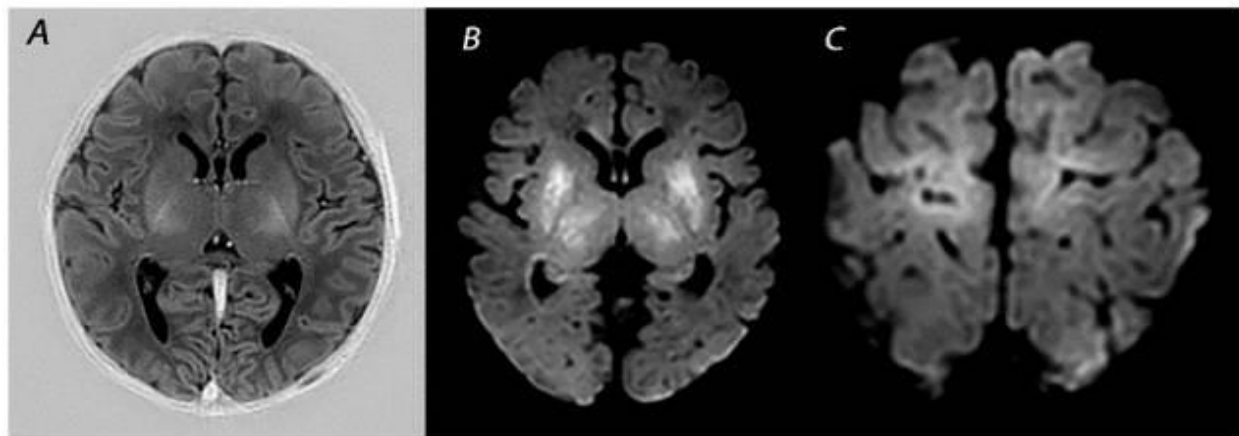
(A), DWI shows extensive diffusion restriction in the basal ganglia and thalami (B), and the perirolandic cortex (C). The infant died after redirection of care.
